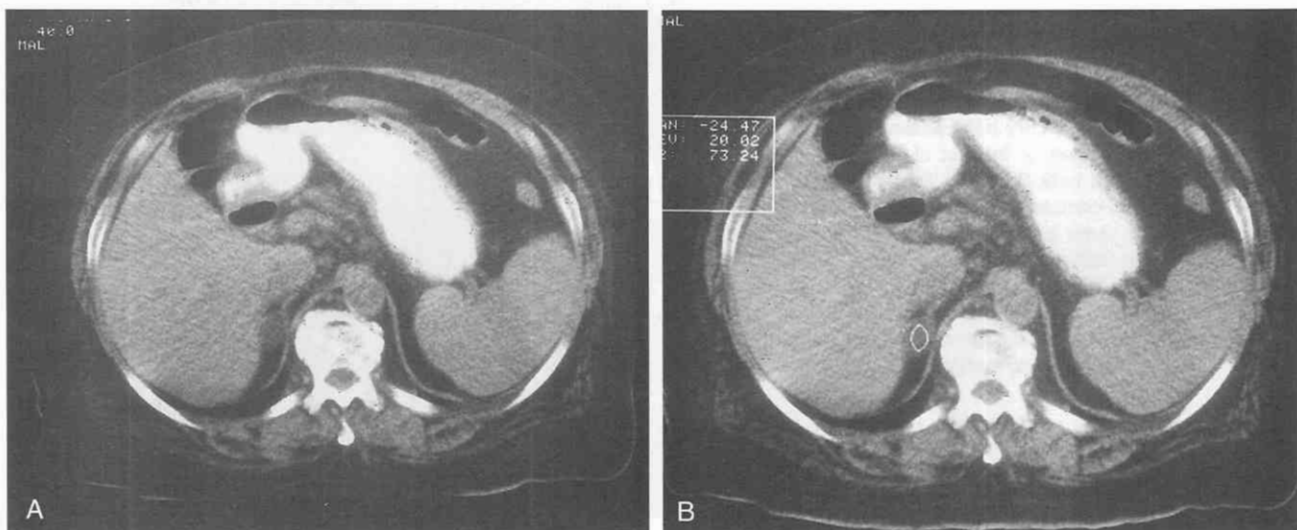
Adenoma. A and B, Non-contrast-enhanced CT scans demonstrate a 1.5-cm low-density mass in the right adrenal gland. The mass measured -24 Hounsfield units (HU), indicating that this is a benign adenoma.
